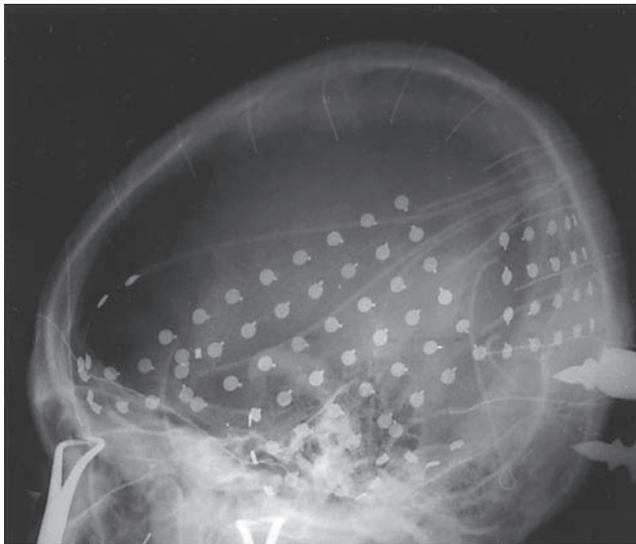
▲ Radiograph of a grid for seizure monitoring. (Courtesy of Frederick Lenz, MD, and Ira Garonzik, MD, The Johns Hopkins University, Baltimore, MD.)
